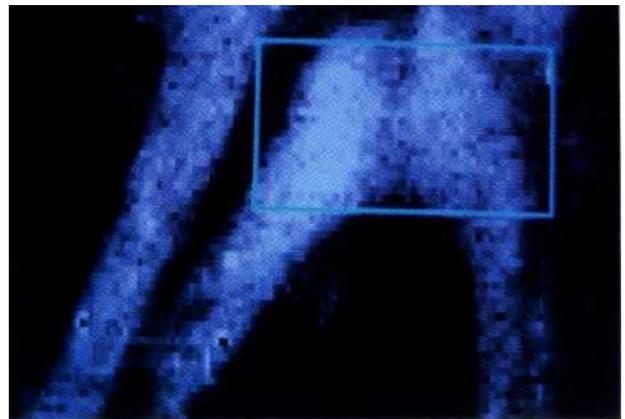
A computer-enhanced digital radiographic image of a dental apex. (Courtesy Trophy U.S.A., Inc.)
